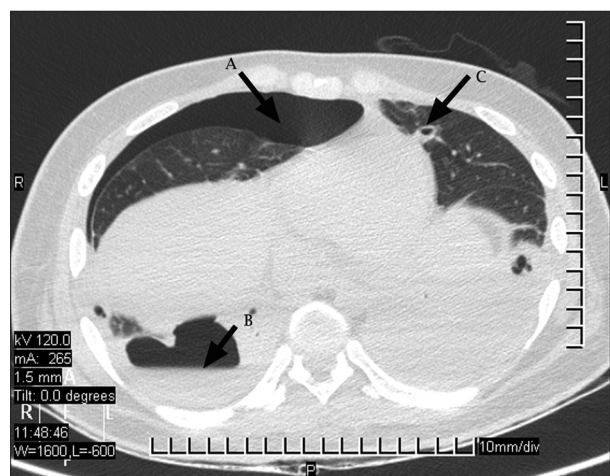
Axial CT image of chest depicting (a) right-sided hydro-pneumothorax with (b) loculation at base and (c) cavitating nodule in left lung
